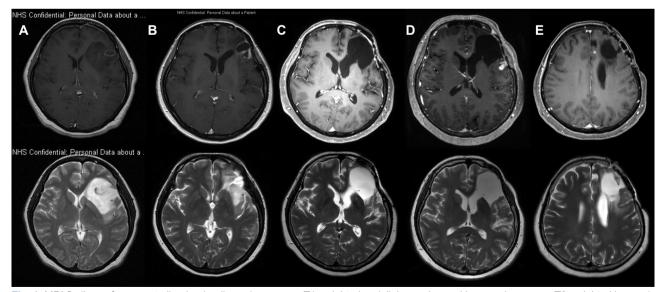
MRI findings of recurrent oligodendroglioma (upper row: T1-weighted gadolinium-enhanced images, lower row: T2-weighted images). These images demonstrate the progression of the tumor through multiple recurrences and malignant transformation into anaplastic oligodendroglioma after the second recurrence. A: Initial diagnosis. B: Recurrence 2.5 years after the initial surgery and adjuvant radiotherapy. C: Postsurgical remission status after the second surgery, followed by chemotherapy, with minimal residual disease. D: The second recurrence, showing leptomeningeal spread confirmed on cerebrospinal fluid cytology and treated with surgery followed by temozolomide. E: Third recurrence observed in the adjacent medial frontal lobe, treated before initiating Wilms tumor 1 immune therapy.
